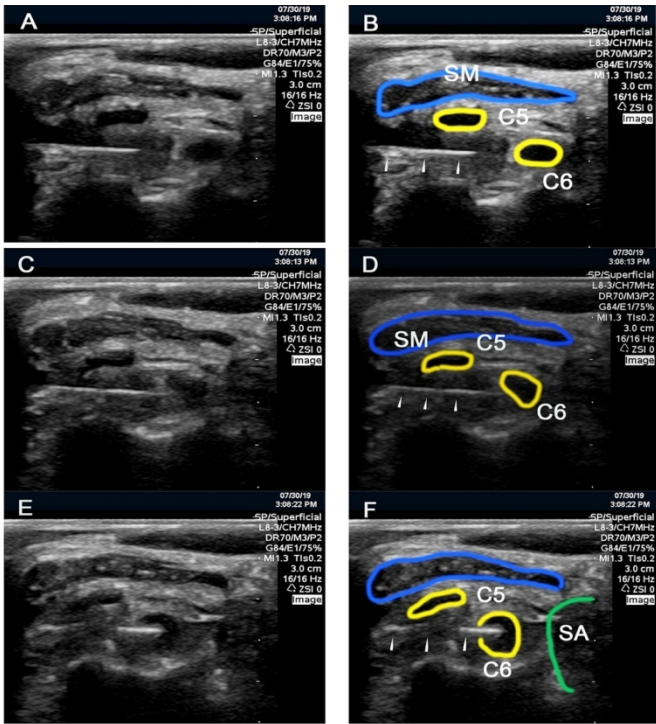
Representative ultrasound images of the right neck of cadaver 3 taken with a 3 to 8MHz transducer over the ventral C5 and C6 interscalene nerve roots. Images are cropped to a depth of 25mm. Image pairs are shown without (left) and with (right) annotation indicating needle position (3 arrowheads), C5 and C6 nerve roots outlined in yellow, scalenus medius (SM) outlined in blue, and scalenus anterior (SA) outlined in green. Images A and B show the needle tip approximately 3 mm from C6. Images C and D show the needle gently contacting epineurium. Images E and F show the needle tip within the subepineurium of C6 and the nerve has expanded secondary to subepineural injection.
